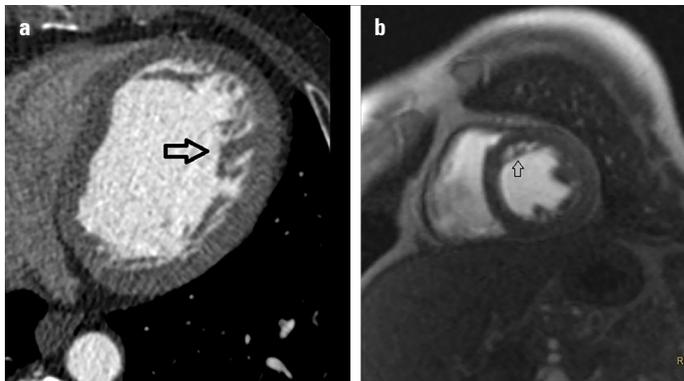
Multidetector computed tomography and cardiac magnetic resonance imaging confirmed the diagnosis of myocardial noncompaction (arrows)
